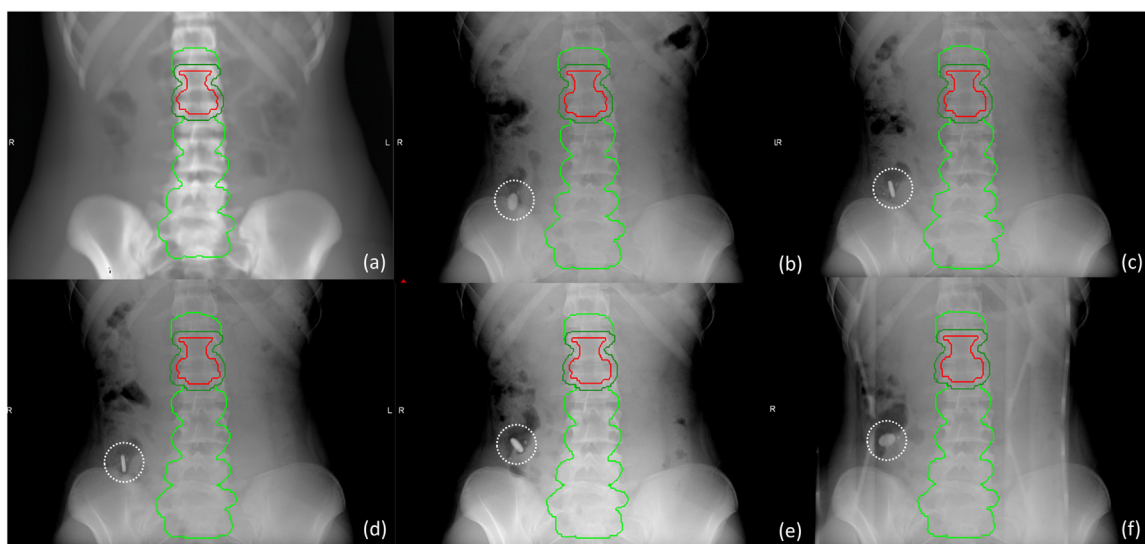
An artificial object detected in the AP radiographs during patient alignment. The fluorescent green color indicates the PTV for the initial treatment, delivering 50.4 Gy_{RBE}. The clinical target volume and PTV for a boost dose of 3.6 Gy_{RBE} are represented by red and green. Digitally reconstructed radiography is used as a (a) reference, whereas AP radiographs were acquired during the initial attempt of (b) patient setup and at different elapsed times of (c) 5.8 minutes, (d) 9.1 minutes, (e) 15.7 minutes, and (f) 29.6 minutes.
